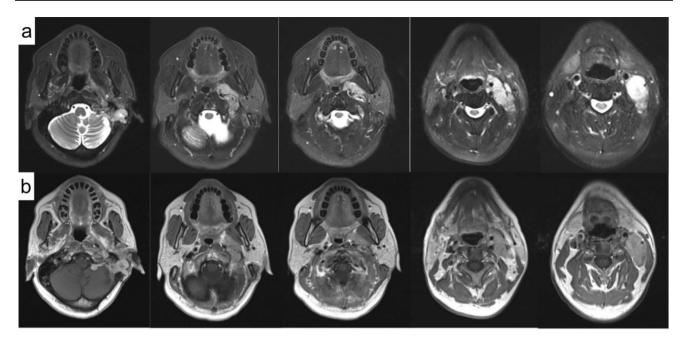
MRI of the head and neck revealed multiple soft tissue masses in the left mastoid process and tentorium cerebelli, with transjugular foramen extension into the left parapharyngeal space and cervical lymph nodes on T2WI sequence (a) and obvious heterogeneous enhancement on T1WI enhanced sequence (b)
